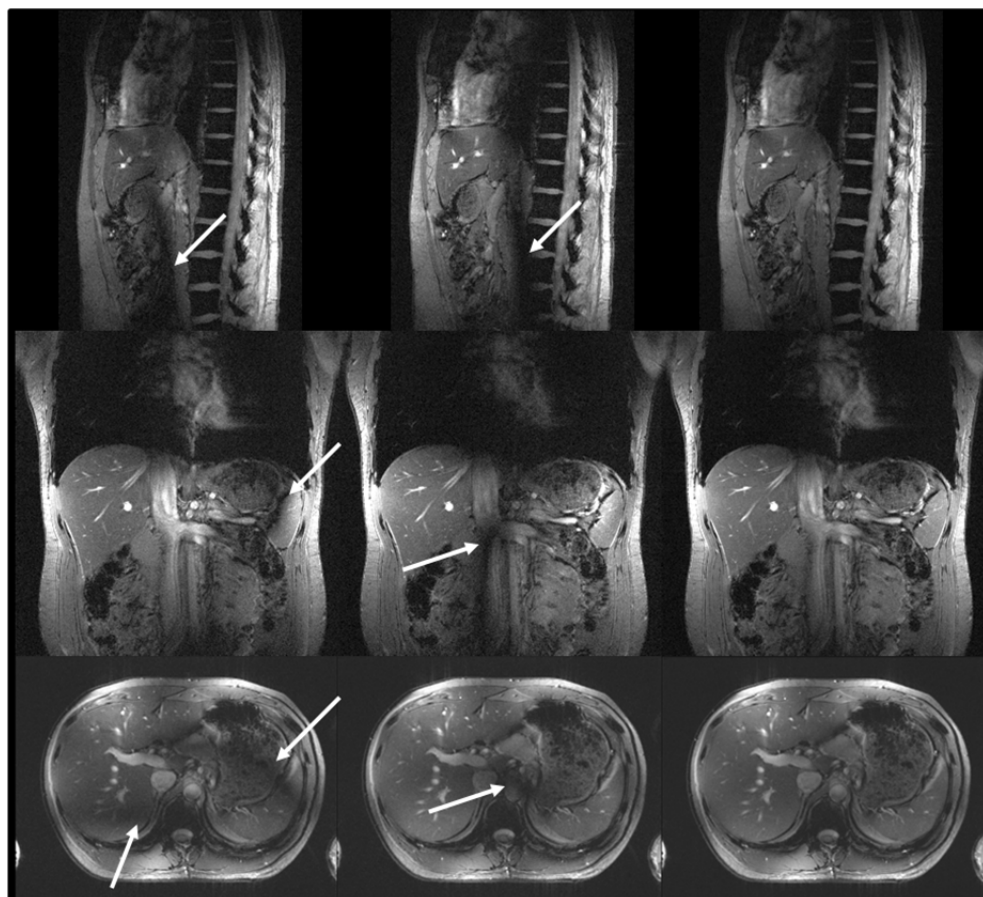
7T T1-weighted gradient echo images in a human volunteer. The images of the two acquired modes (left and middle column) show significant signal dropouts (arrows), the images reconstructed with TIAMO combined reconstruction in the right column show no significant dropouts. Note: the images are not intensity corrected.
